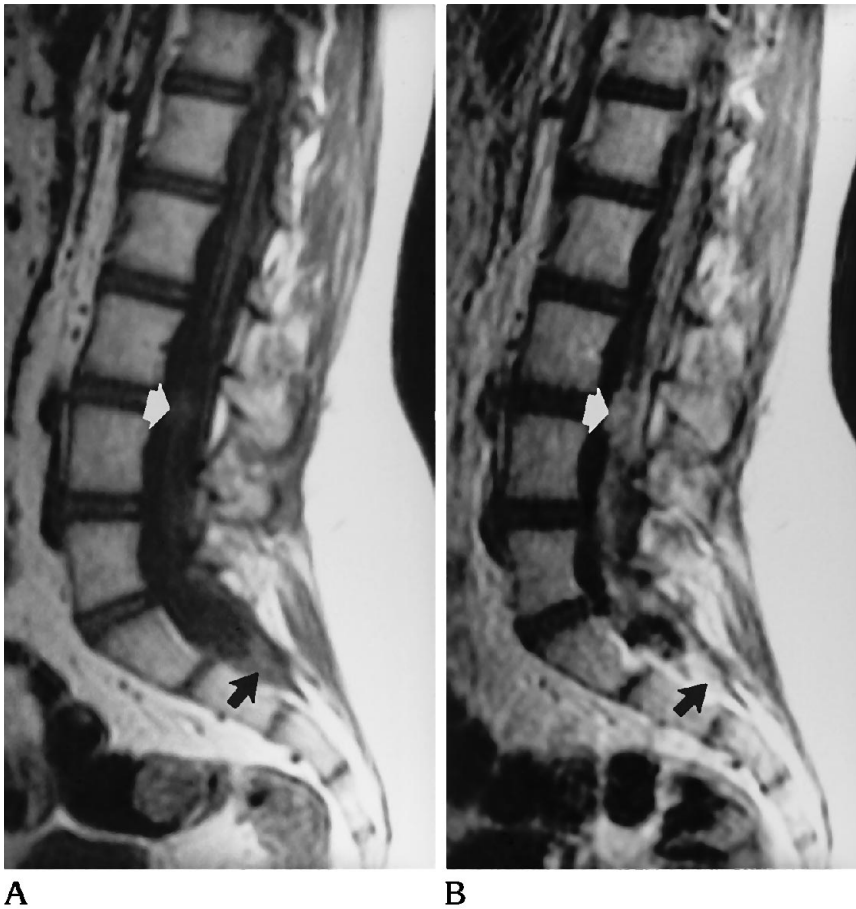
Preenhancement (A) and postenhancement (B) sagittal T1-weighted spin-echo images (500/11) of the lumbosacral spine. Note the heterogeneously enhanced nodules on the cauda equina (*white arrows*) and at the terminal thecal sac (*black arrows*).
